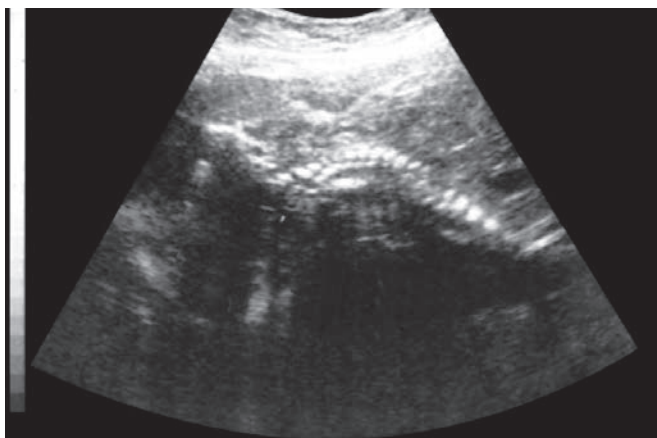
Ultrasound examination showing breech gestation
